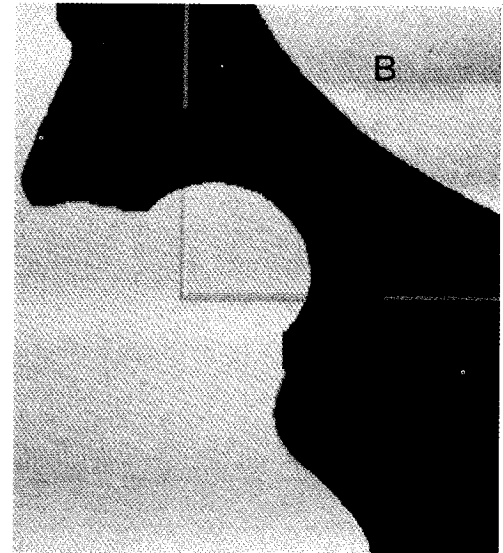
X-rays of three areas of prosthetic socket.
